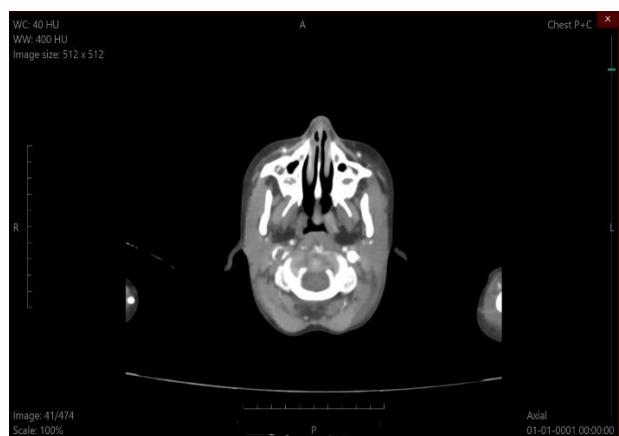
Contrast CT scan of neck vessels showing total occlusion of right IJV by thrombus.
